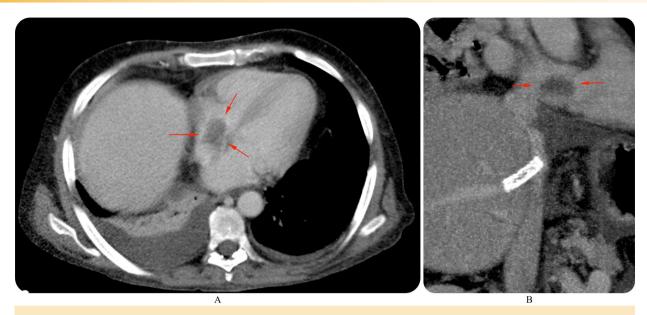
Hypodense thrombus (arrows) seen in the right atrium in the axial (A) and coronal MPR (B) CT images
